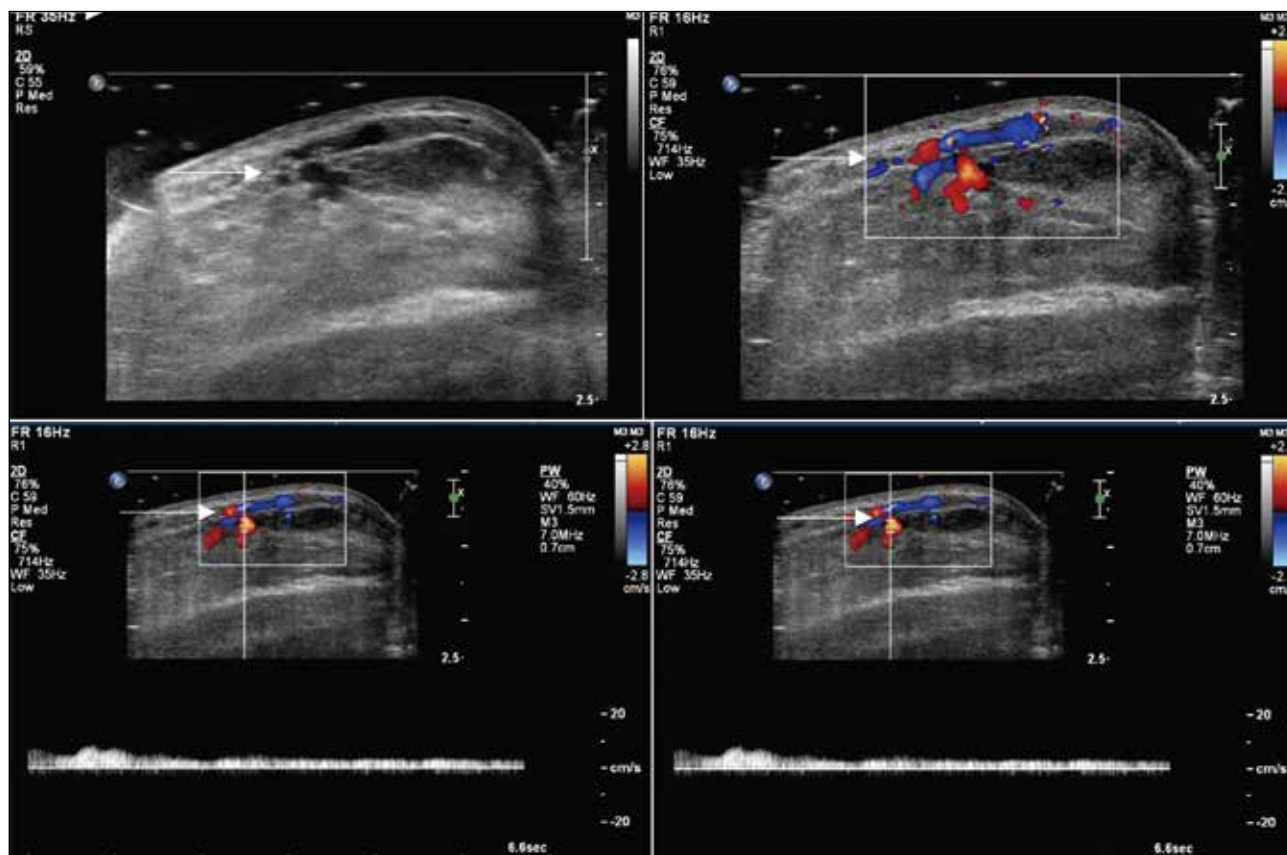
Venous malformation. Ultrasound of the left anterior chest wall. A hypoechoic area with tubular structures demonstrating venous flow patterns is observed (arrows). The total extent of involvement measures at least 4.3 cm along its greatest dimension.
